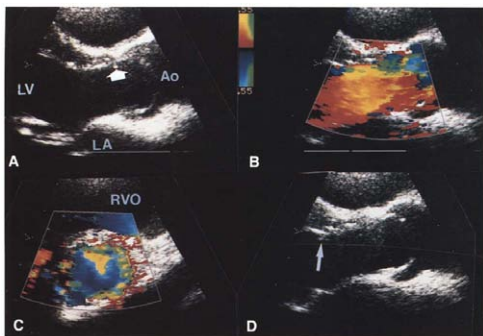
Echocardiograms of the left ventricular (LV) outflow tract 5 years after resection of a crescent-like subaortic obstruction. A, There is a mild recurrence of the discrete subaortic stenosis (arrow). B, Color flow map showing flow separation with variance (green) anterior in the outflow tract, originating well below the region of the subaortic obstruction. C, Color map of the outflow tract in the short-axis view shows the cloud of turbulent flow to adhere to the septum where previously a crescent-like obstruction had been resected. D, The cause of the turbulence could be identified as a small ridge (arrow), which was the offshoot of a spiral ventricular band. Other abbreviations as in Figure 1.
